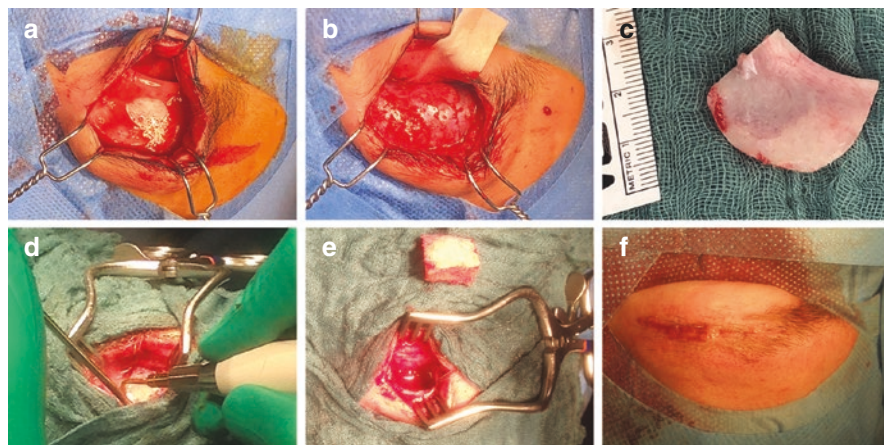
The surgical technique includes a lateral two third eyebrow skin incision and soft tissue retraction (a). The craniotomy is performed using an ultrasonic bone incision device (Mectron, Genova, Italy) (d) to apply a supraorbital craniotomy with inclusion of the orbital rim to expose the dura and the periorbital layer (b, c, e). The skin closure is achieved by periosteum and muscle adaptation, subcutaneous sutures, and skin glue (f)
